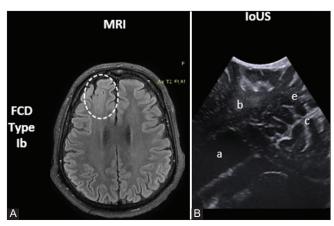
FCD TYPE Ib A - MRI Flair in Axial view depicting affected zone of RT frontal FCD Type Ib (Dashed lines). B: Highlighting IoUS FCD Lesion with related anatomical structures: a- Rt anterior horn of lateral ventricle, b- FCD Type Ib, c-Interhemispheric Fissure, e Superior frontal gyrus.
